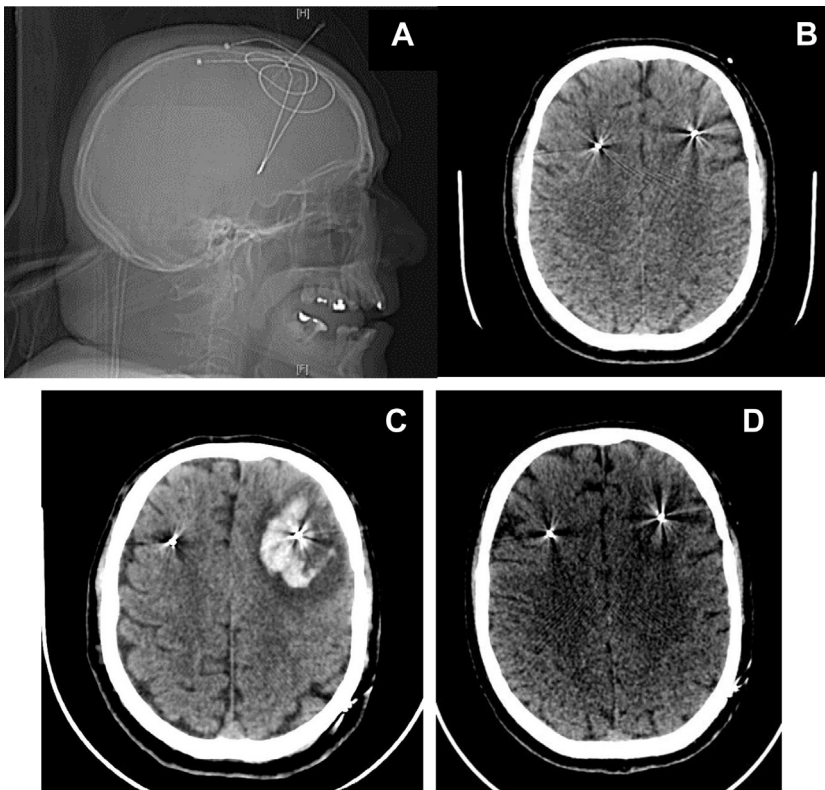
(A, B) The electrode trajectory was calculated to pass through the anterior part of the middle frontal gyrus (Brodmann area 9/46) and the anterior limb of the internal capsule before ending in the ventral striatum, nucleus accumbens. (C) Computed tomography showed a voluminous left frontal hematoma along the electrode (diameter 55 mm) with perihematomal edema, a deletion of cortical sulci, and a mild deflection of the midline. (D) After 1 month, computed tomography showed a resorption of the hematoma with the presence of a sequellar hypodense range.
